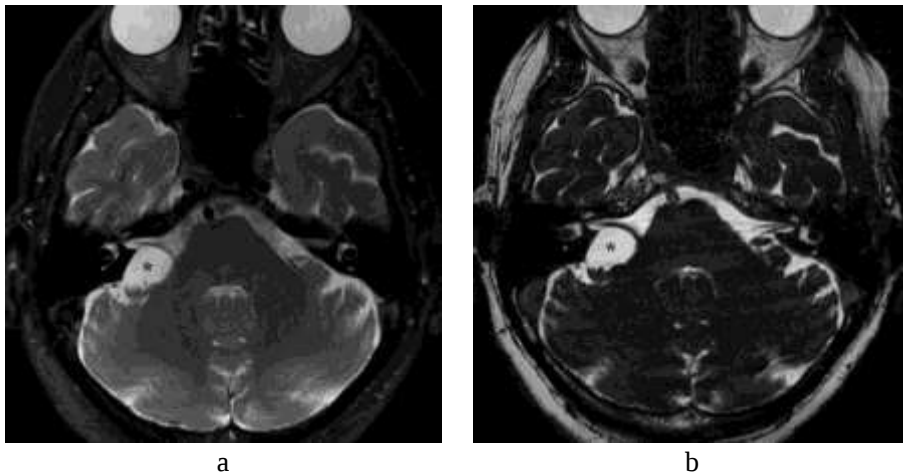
Arachnoid cyst; axial T2-weighted with fat-saturation (a) and high resolution CISS (b) sequences at the level of IACs. A lesion occupying the right CPA with CSF like signal on all pulse sequences is shown (asterisk); the cyst causes mild mass effect on the intracisternal tract of the vestibulocochlear nerve.
